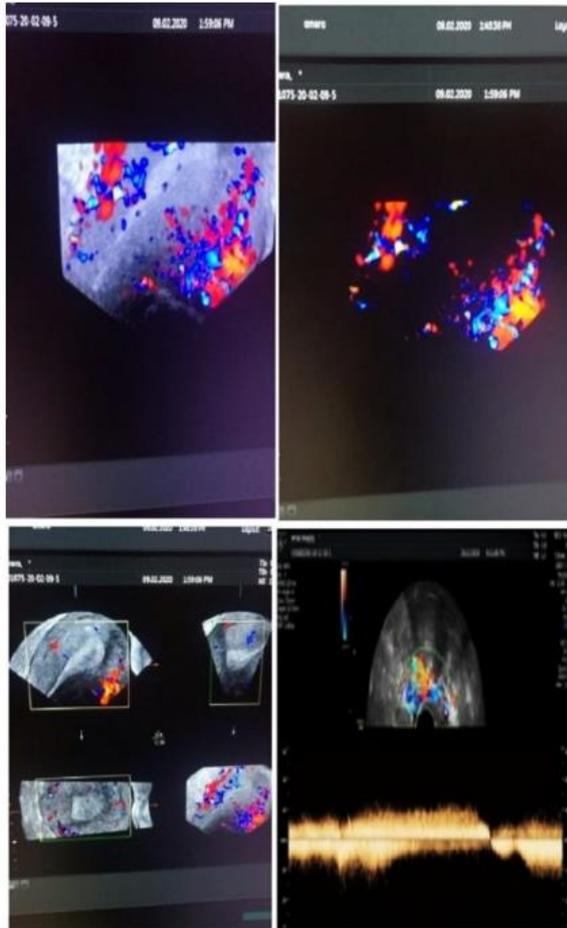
Transvaginal color & 3D Power Doppler showing bilateral uterine varicosities with bilateral venous reflux.
